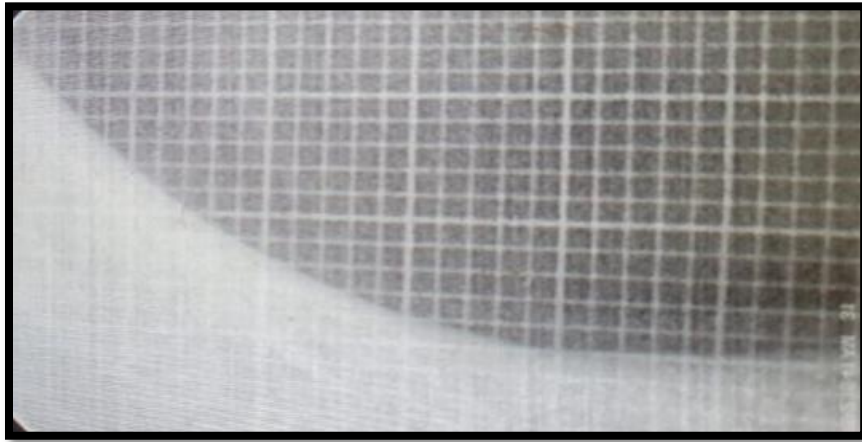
Pre-op radiograph with grid
